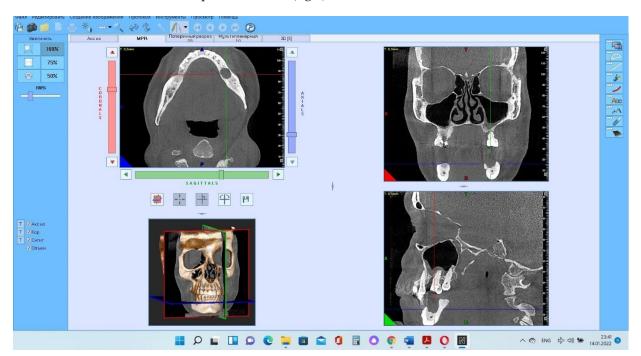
CT-scan after dental implant loss before bone plasty after 7 years surgery
